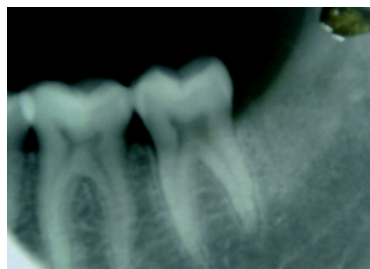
Post operative (3 months) radiograph of graft site
